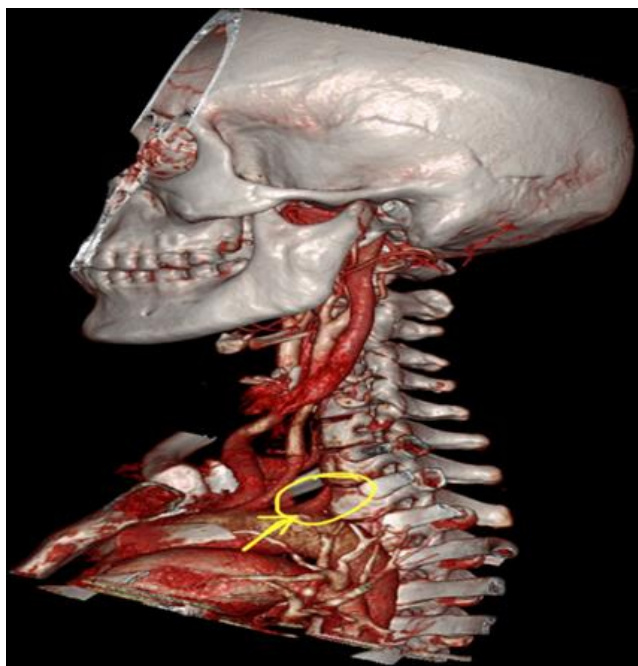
Three dimensional volume- rendered helical CT- angiogram of neck showing the aortic arch and major branch vessels. irregular narrowing of V1 segment
